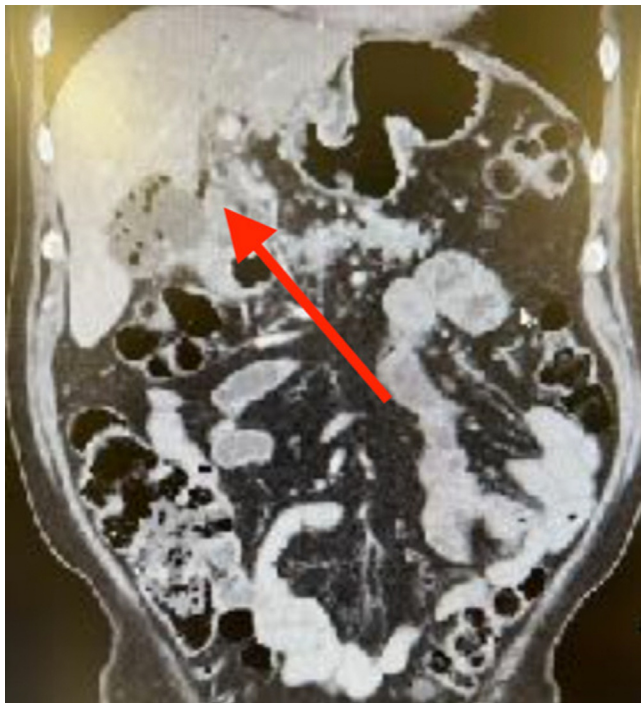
Coronal cut of initial CT scan demonstrating pneumobilia involving the gallbladder lumen and common hepatic duct.
